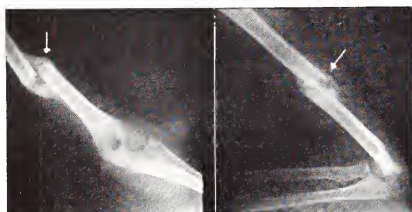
X-ray taken two months after injury shows fracture of the mid-portion of the humerus with considerable callus at the site of the fracture.
